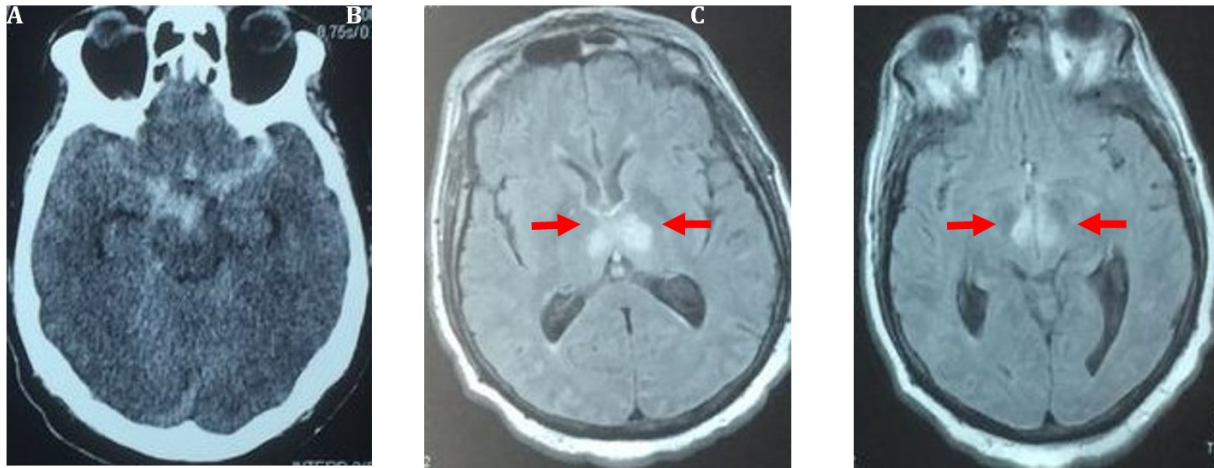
Imaging studies A: non contrast brain CT showing a diffuse subarachnoid hemorrhage in the basal cisterns. B: T1/FLAIR signal weighed axial MRI demonstrating hyperdensities of bilateral paramedian thalami and C: Hyperdensities of bilateral midbrain consistent with bilateral thalamus and midbrain infarction [red arrow].
